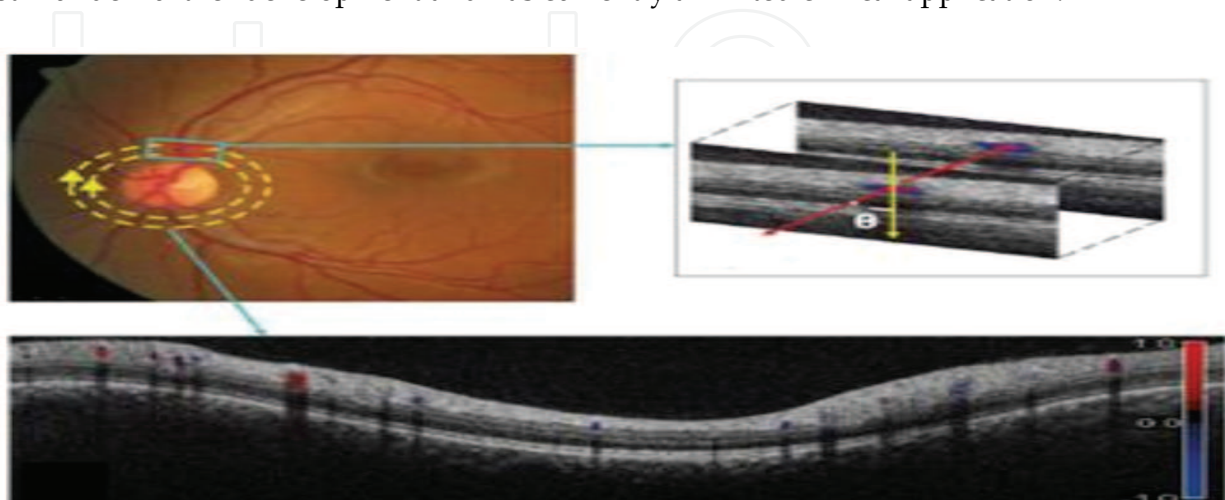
Doppler OCT image printout (courtesy of David Huang)
